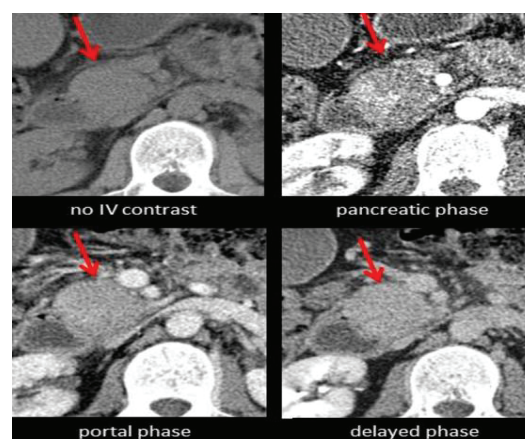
CT images in different phases-Autoimmune pancreatitis
